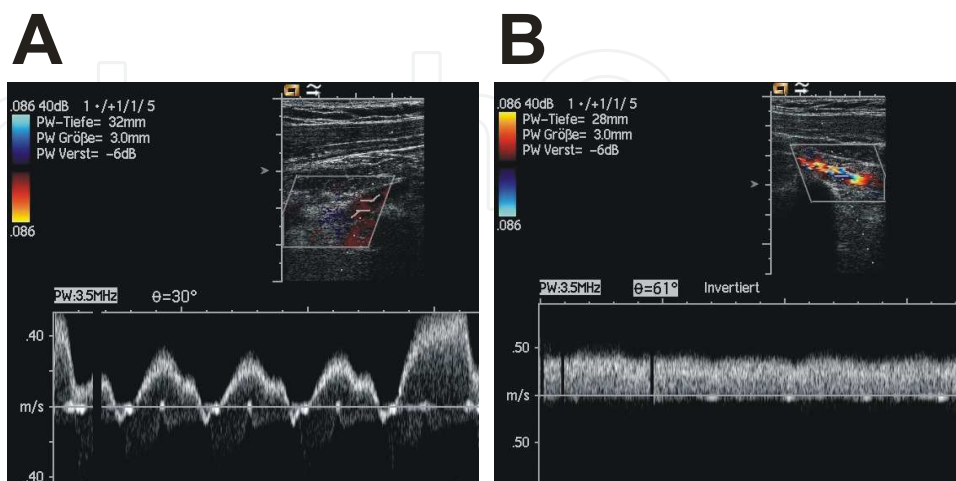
Indirect sonographic diagnosis of a non-recent thrombosis of the left subclavian vein with partial recanalisation. Normal venous flow with cardiac and respiratory modulation in the right subclavian vein (A) compared to linear flow in the left subclavian vein (B).
